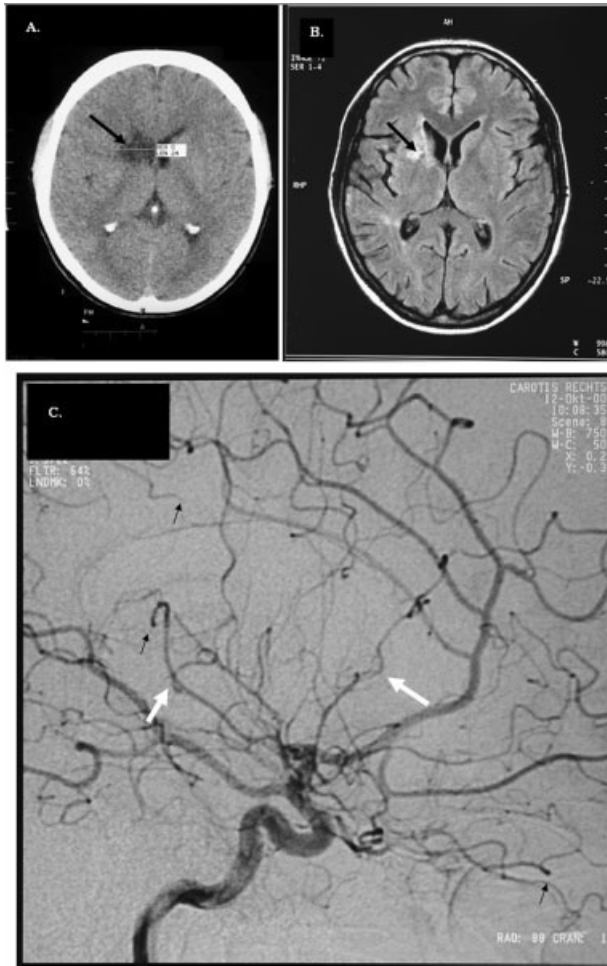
Cerebral CT, MRI, and angiography scans. A: CT scan. Hypodense lesion in the right temporal lobe. B: FLAIR imaging. Signal-intense lesion in the caudate nucleus, the internal capsule, and the lenticular nucleus. C: Cerebral digital subtraction angiography (right carotid artery, sagittal view) revealing multiple typical signs of cerebral vasculitis, including nonspecific multifocal segmental dilations and narrowing (white arrows) affecting all three major vascular territories. Furthermore, there are multiple occlusions (black arrows).
